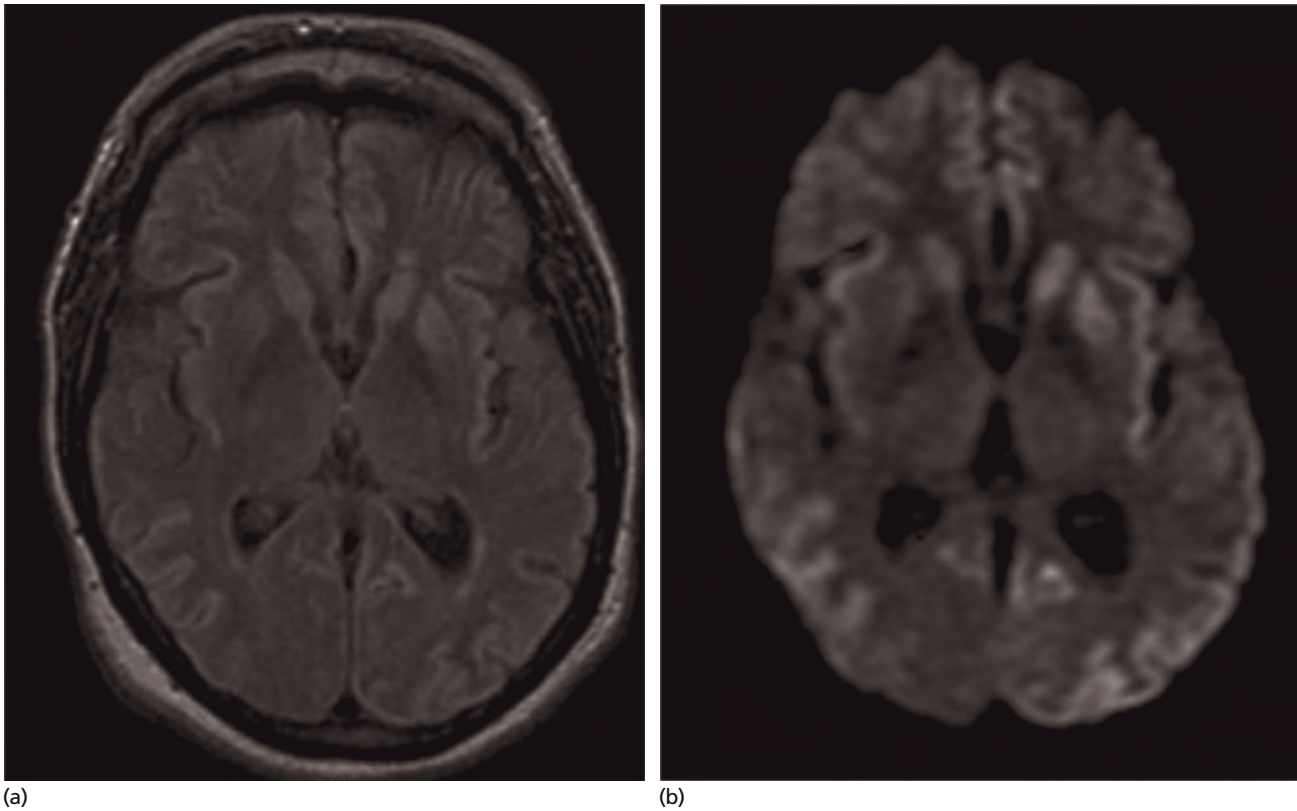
Sporadic CJD: MRI demonstrates typical increased signal intensity in the caudate and putamen bilaterally and widespread increased cortical signal intensity involving the occipital, frontal, temporal and insula cortex on FLAIR (a) and DWI sequences (b). The cortical signal changes are more apparent on the DWI images.
